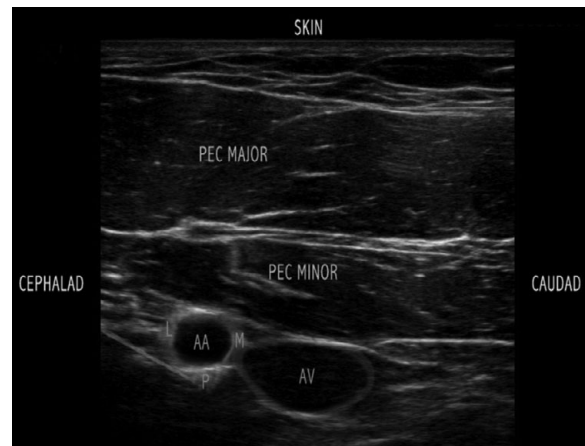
Ultrasound anatomy of the infraclavicular block. AA, Axillary Artery; AV, Axillary Vein; L, Lateral Cord; M, Medial Cord; P, Posterior Cord
